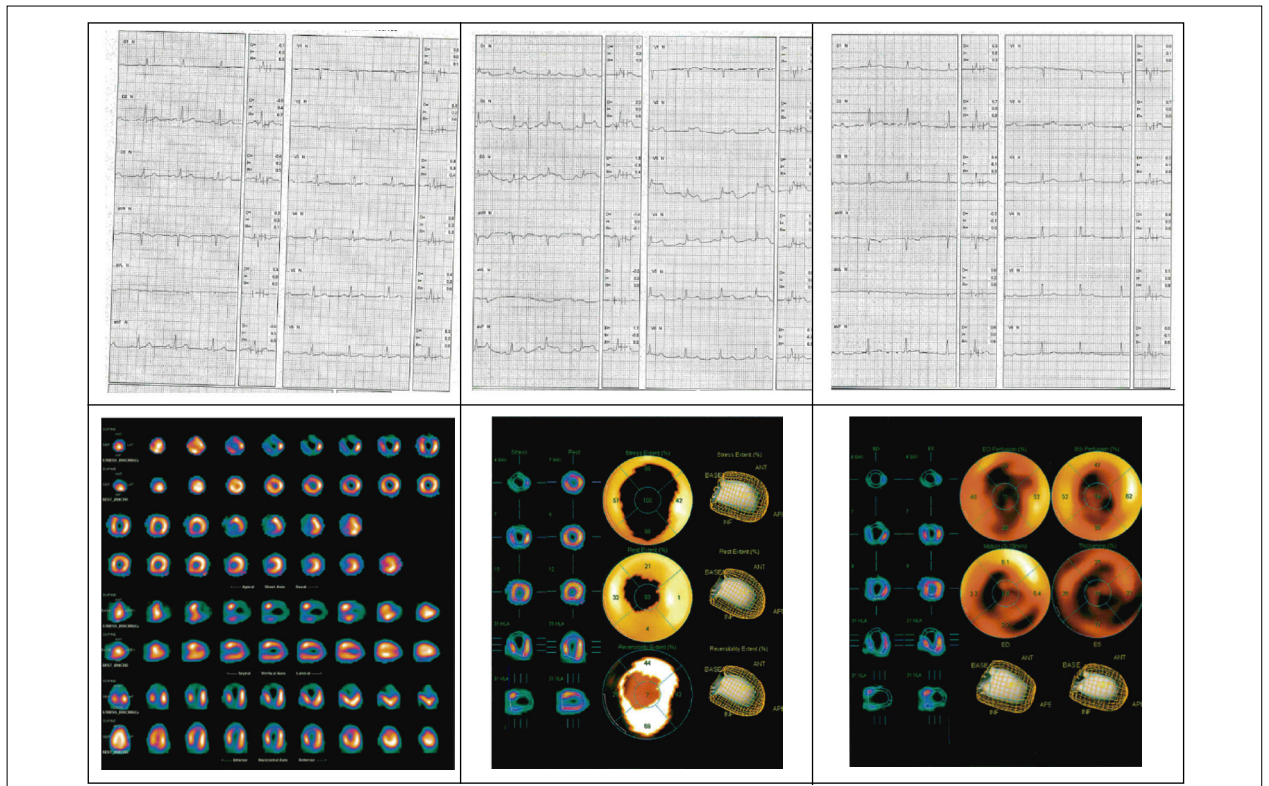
Myocardial scintigraphy.
